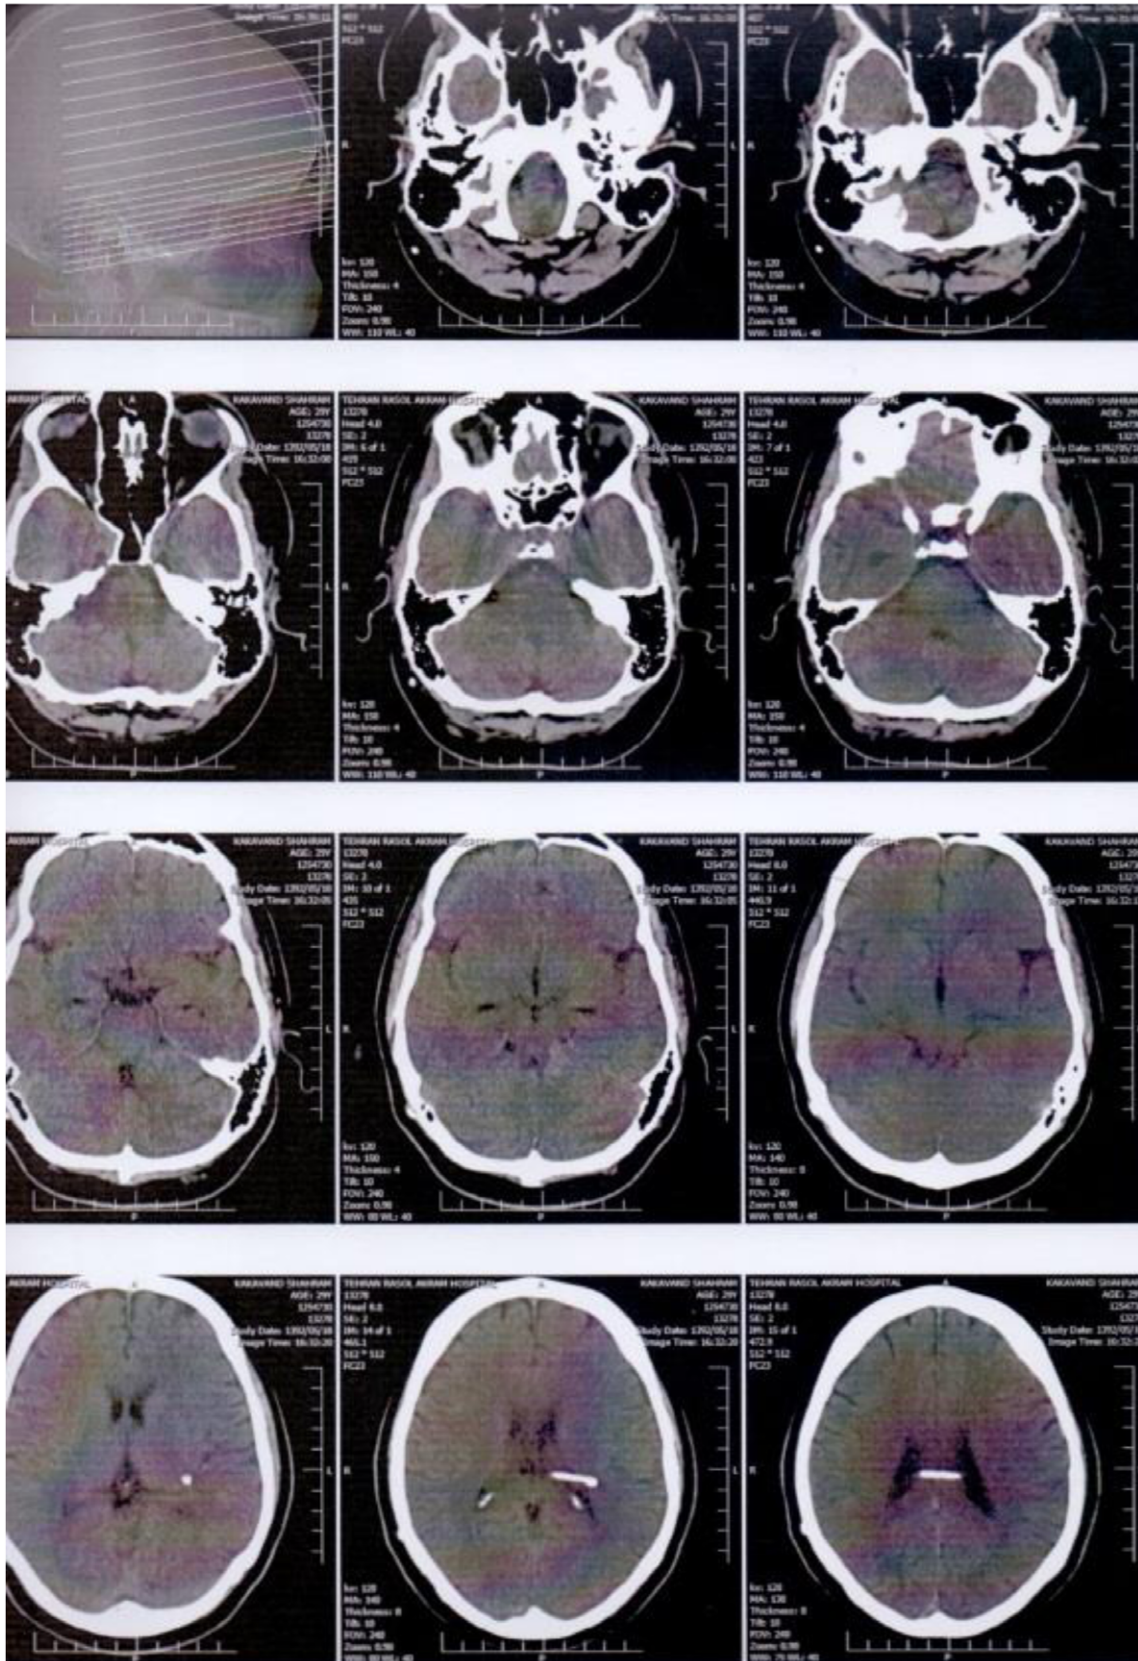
CT scan imaging of the brain. No signs of the tumour were observed.
